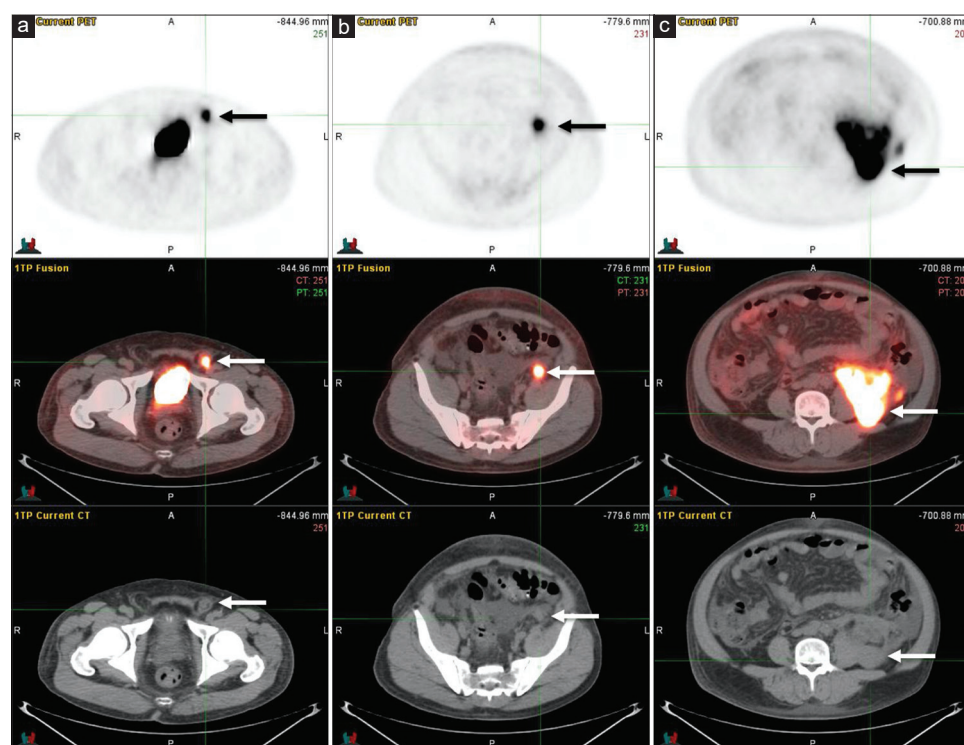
Panels (a-c) are axial PET, fused axial PET/CT and axial CT images at multiple levels (from inferior to superior respectively) showing hypermetabolic tumor foci extending along the left inguinal canal, to the retroperitoneal space, and the left perinephric space
